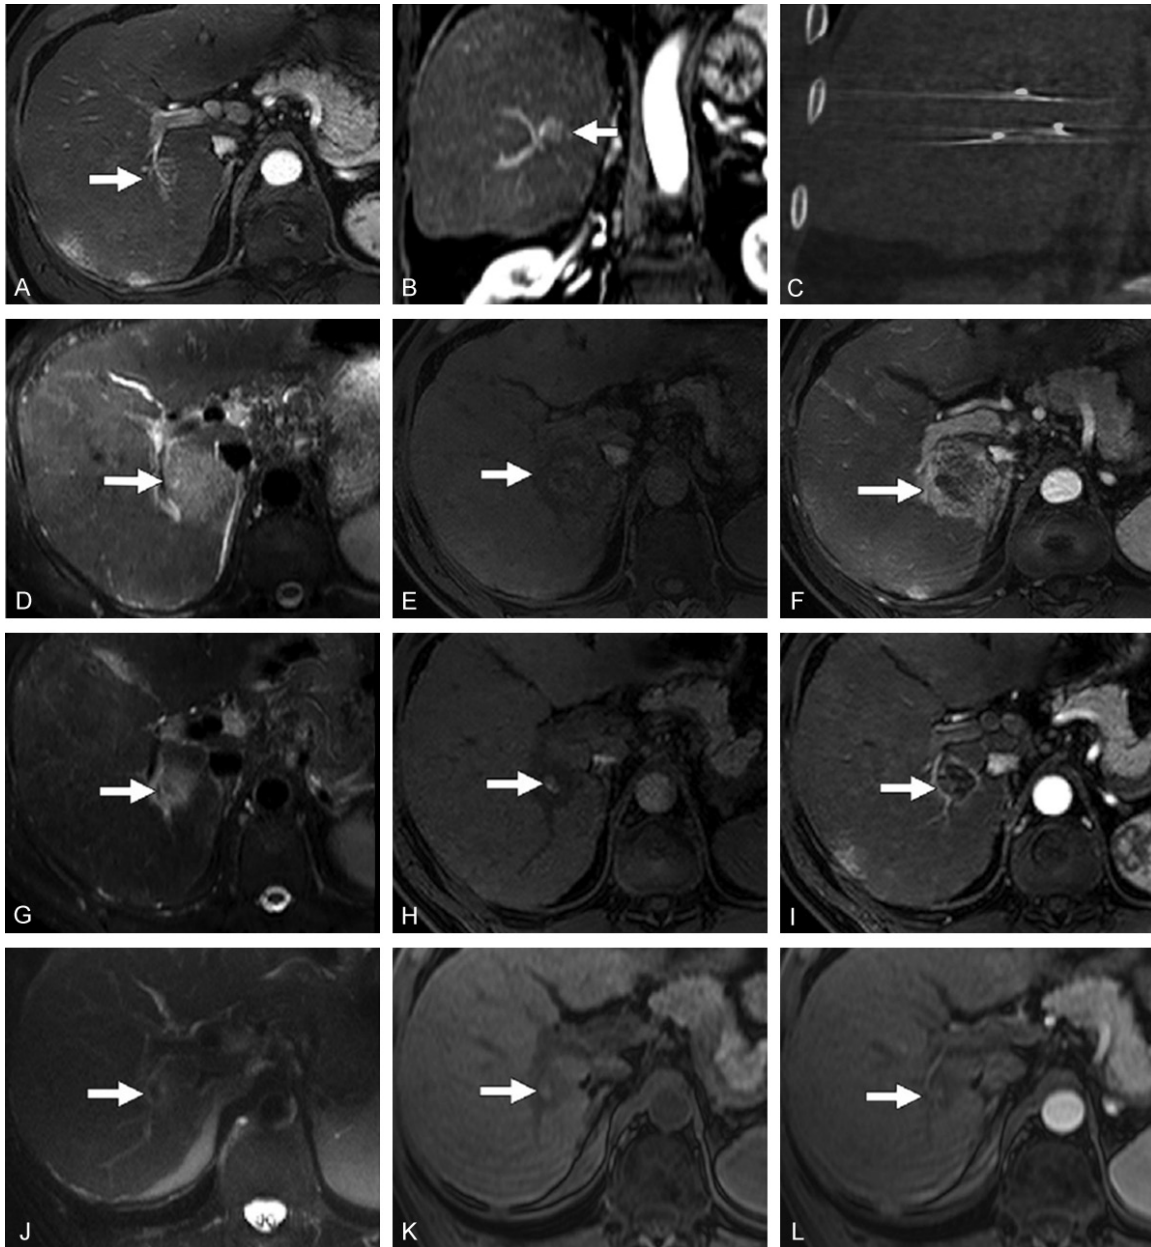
Typical MRI appearance of HCC after IRE. (A, B) Baseline axial and coronal contrast-enhanced T1-weighted MRI acquired in the arterial phase showing an HCC in the right hepatic lobe. (C) Post-IRE CT showing the electrodes. (D-F) Images acquired 24 hours after IRE, showing an ablation area that is hyperintense at T2-weighted MRI (D), slightly hyperintense with a hypointense margin at unenhanced T1-weighted MRI (E) and hypointense with hyperintense margin at contrast-enhanced T1-weighted MRI during the arterial phase (F). (G-I) T2-weighted MRI (G), unenhanced (H) and contrast-enhanced (I) T1-weighted MRI acquired 30 days after IRE, showing similar signals but reduced dimensions with respect to the previous time point. (J-L) T2-weighted MRI (J), unenhanced (K) and contrast-enhanced (L) T1-weighted MRI acquired 120 days after IRE, showing a further reduction of the ablation zone and no contrast enhancement. Reproduced with permission from [19].
